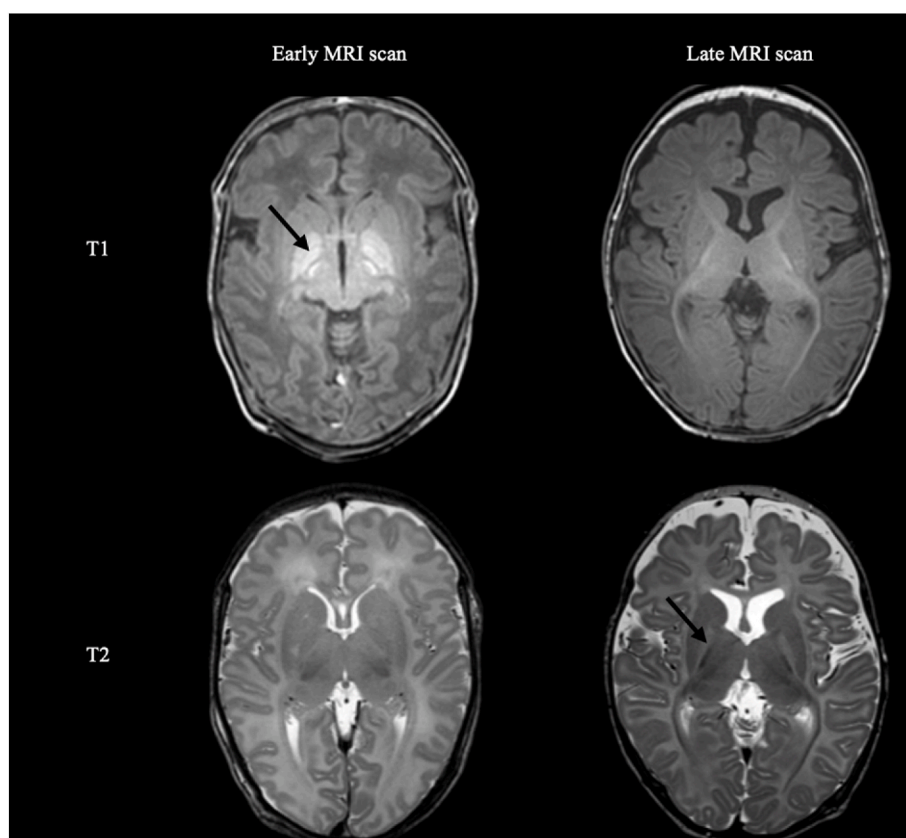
Early versus late MRI scan
